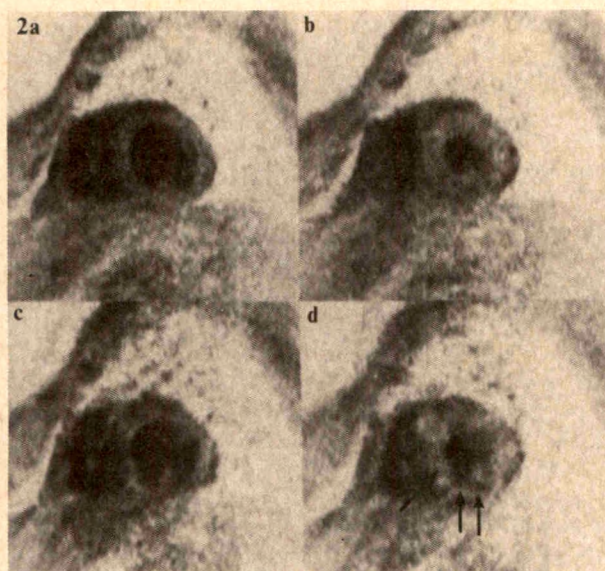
Example of inferior reversible wall motion and perfusion abnormality. Magnetic resonance images are in reverse video format, contrasting grey myocardium against black intraventricular blood. Magnetic resonance short-axis images at baseline (*a* and *b*) and during dobutamine stress (*c* and *d*). Left images are at end-diastole (*a* and *c*), and right images are at end-systole (*b* and *d*). Baseline contraction pattern is normal with uniform thickening (*b*), but during dobutamine stress (*d*), there is abnormal contraction and thickening of inferior wall (short arrows) and lower septum (long arrow). Corresponding thallium perfusion short-axis tomograms during stress (*e*) and after redistribution (*f*) are shown. Note reversible inferoseptal perfusion defect (arrow) and close correspondence with wall motion abnormality. Patient had right coronary artery disease.
